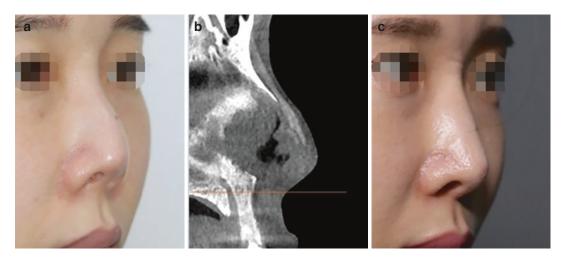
Supratip fullness was shown due to two pieces of silicone. (a) Preoperative view, (b) preoperative CT scan, and (c) postoperative view
